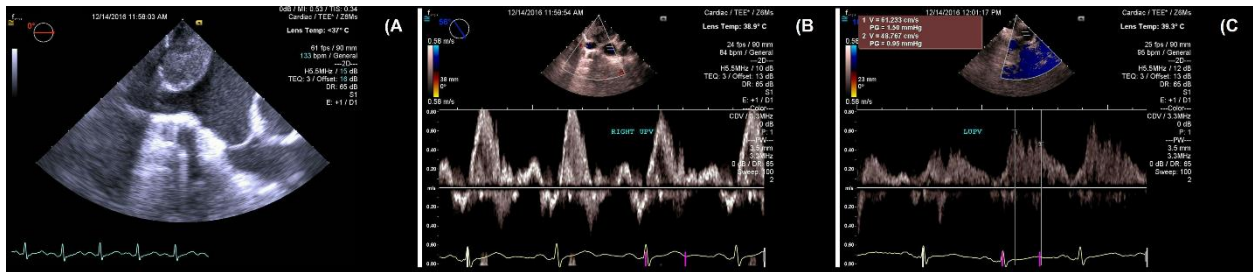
A) Encapsulated mass in the left atrium in the trans-oesophageal echocardiography view. B) Normal flow in the right upper pulmonary vein, not obstructed by the mass. C) Normal flow in the left upper pulmonary vein, not obstructed by the mass.
